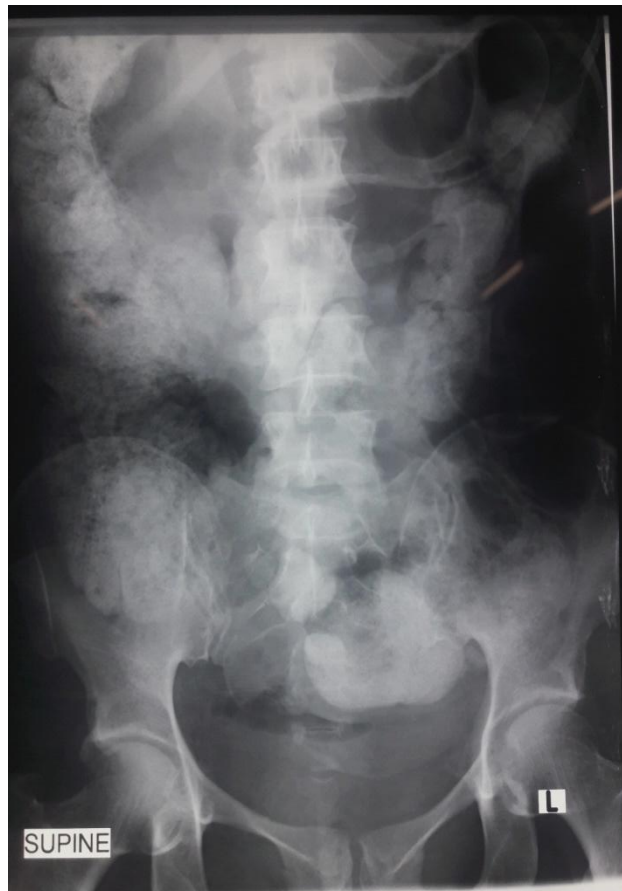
Supine abdomen radiography showed marked large bowel fecal loading with a mottled gas appearance and hyperlucency in the upper abdomen with gas outlining both sides of the bowel wall ('Rigler's sign') in keeping with intra-abdominal free air
